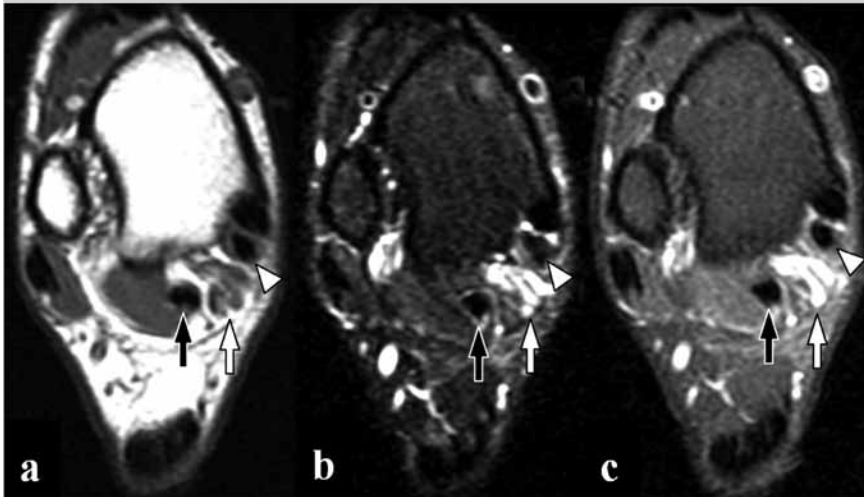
Axial T1-weighted (a), fat-suppressed T2-weighted (b), and Gd-enhanced fat-suppressed T1-weighted (c) MR images demonstrate varicose veins (white arrow) within the tarsal tunnel, between the flexor digitorum longus (arrowhead) and flexor hallucis longus tendons (black arrow).
